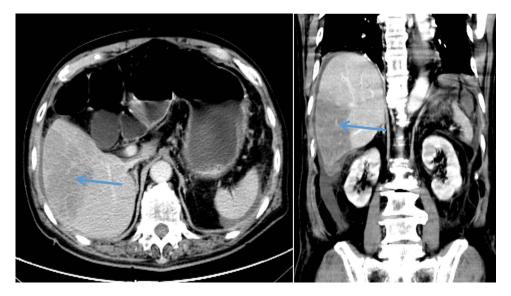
The lesion density on enhanced scan showed no obvious enhancement, and the density was significantly lower than that of normal liver parenchyma, with no obvious space-occupying effect. Small blood vessels could be seen in the lesion, and no capsule could be seen (Left figure). Coronal view showing wedge-shaped lesions in the liver (fan-shaped changes) (Right figure). The left blue arrow indicates the liver infarction lesion seen on the axial enhanced CT, while the right blue arrow indicates the liver infarction lesion seen on the coronal view.
